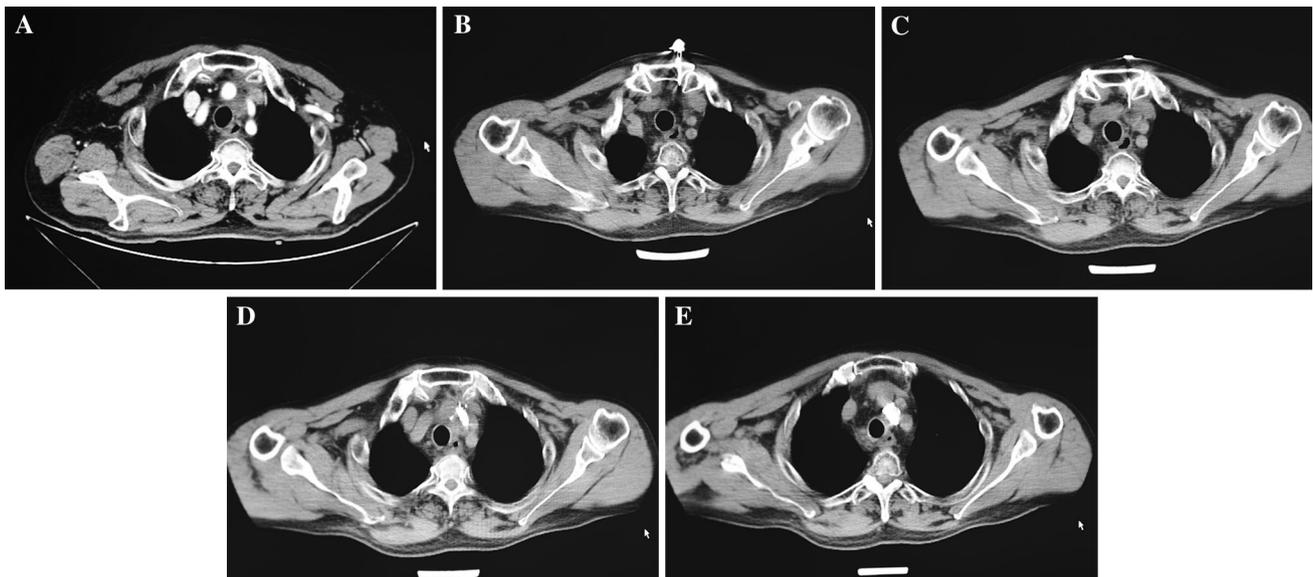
a Patient #3 (primary esophageal carcinoma), enhanced CT scan of post-radiotherapy mediastinal lymph node metastasis (region 2L). b Patient #3 (primary esophageal carcinoma), post-radiotherapy mediastinal lymph node metastasis (region 2L) during thoracostomy needle penetration. c Patient #3 (primary esophageal carcinoma), post-radiotherapy mediastinal lymph node metastasis (region 2L)
